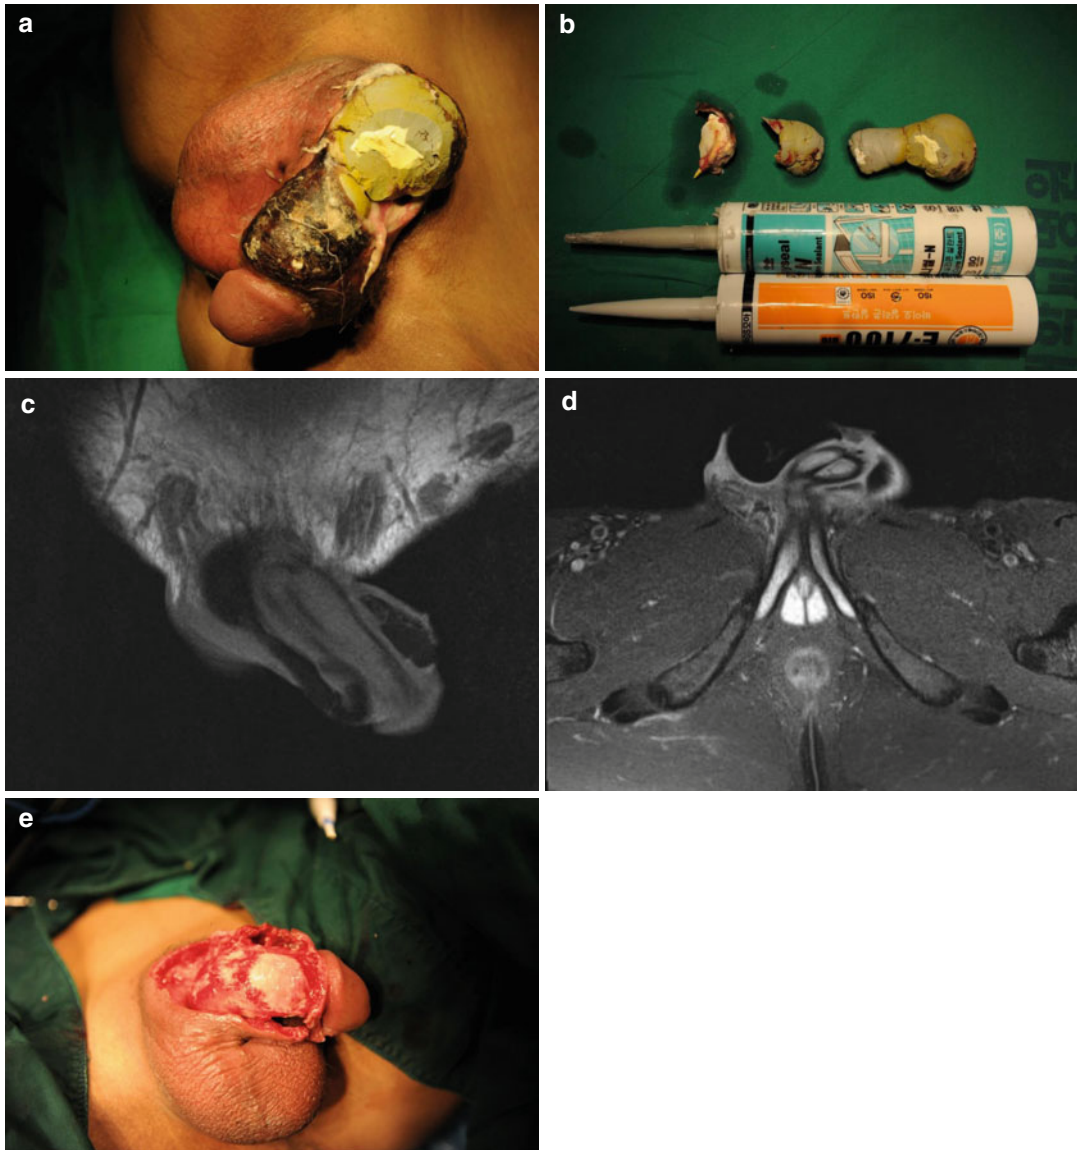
Perioperative findings, silicone, and MRI (a) necrosis of penile skin and exposed silicone. (b) Removed silicone masses and industrial silicones. (c) MRI of multiple silicone masses (*yellow solid arrows*), (d) right
